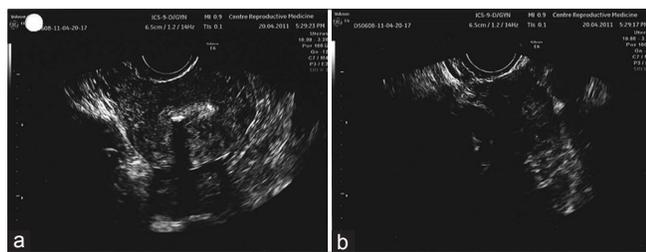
Transvaginal ultrasound with 14 MHz probe demonstrating a calcified endometrial polyp, (a) (see acoustic shadowing b)
